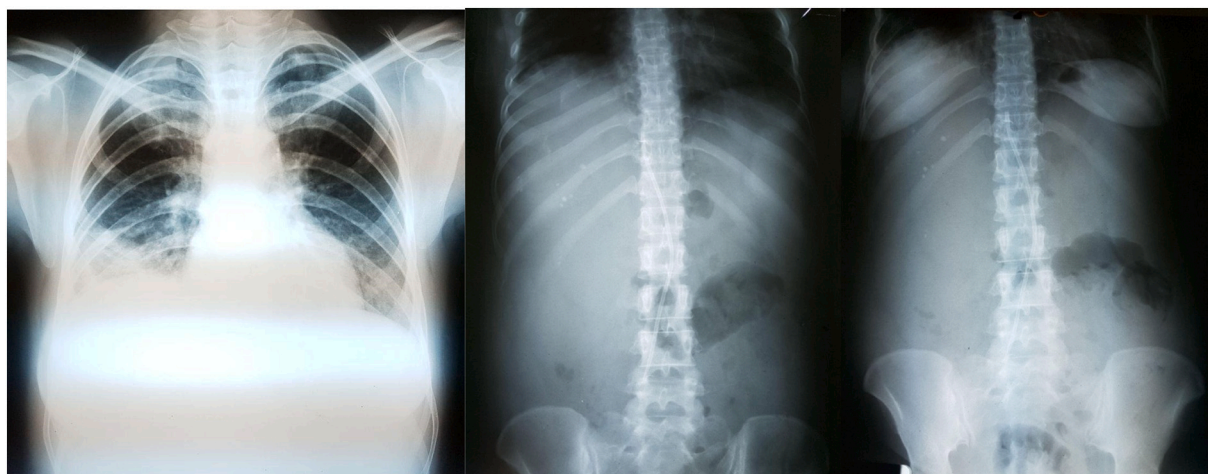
Chest X-ray (left), Abdominal X-rays supine (middle) and upright (right) with no signs of pneumoperitoneum and perforation. There is note of right basal density probably due to effusion or subdiaphragmatic fluid.
